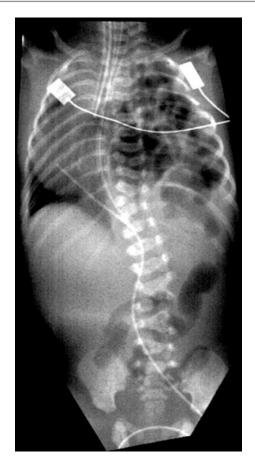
Chest X-ray of newborn with left side CDH Bochdalek defect. Note bowel contents in left thoracic cavity, mediastinal shift and dextrocardia
